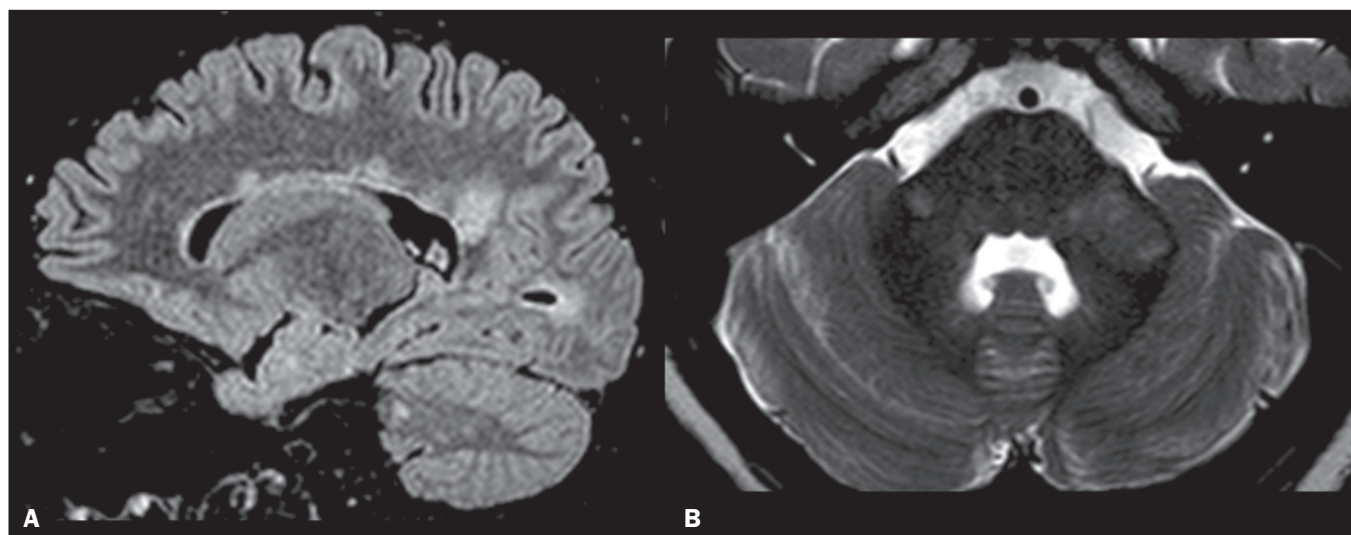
MS. A: Sagittal FLAIR sequence showing callosal lesions perpendicular to the ventricular wall. Note also the lesions in the occipital and cerebellar white matter. B: Axial T2WI showing bilateral hyperintense lesions (more conspicuous on the left side) involving the MCPs.
